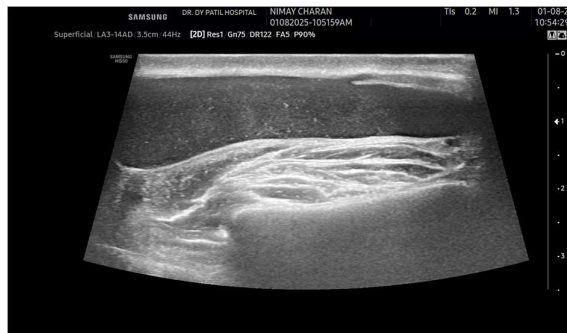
Grayscale ultrasound image (transverse view) of the left parotid region demonstrating a dilated anechoic parotid duct (yellow arrow) anterior to the masseter.
